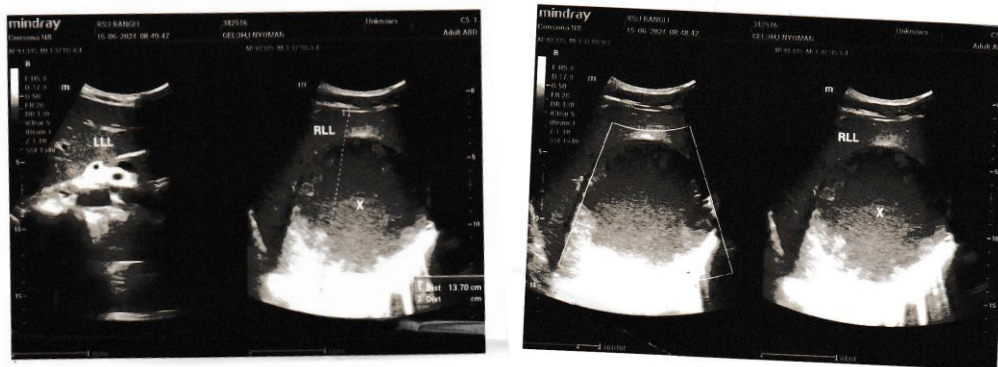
Abdominal *ultrasonography* (USG) examination results
